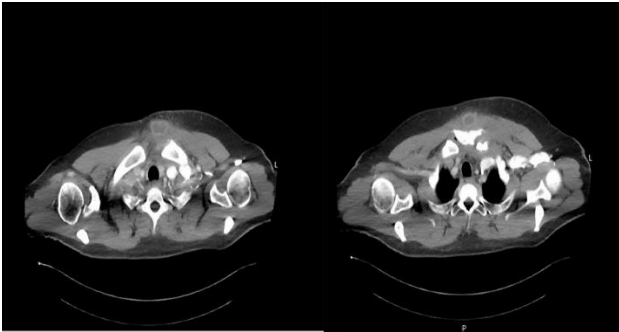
CT chest with contrast revealed a poorly defined soft tissue mass ventral to the sternal manubrium.
